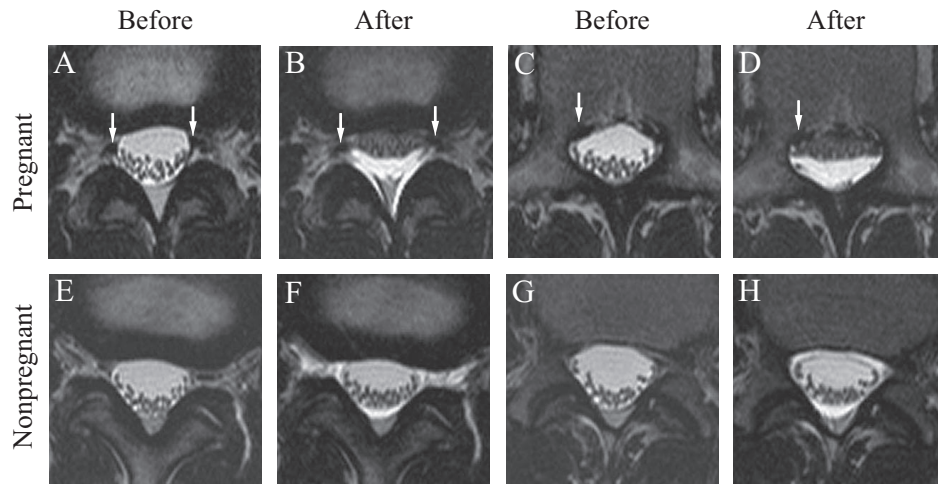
Magnetic resonance (MR) images (A, C, E, G) before and (B, D, F, H) after epidural saline (10 ml) injection in a 27-yr-old pregnant woman at 39 weeks' gestation, whose cerebrospinal fluid volume decreased from 40.5 ml to 30.1 ml (top; A-D), and in a 22-yr-old nonpregnant woman, whose cerebrospinal fluid volume decreased from 35.1 ml to 31.3 ml (bottom; E-H). In these axial images, anterior is at the top of the figure and anatomic right is at the left of the figure. (Top; A-D) The epidural venous plexus was enlarged, which is a common finding among pregnant women (arrows). (A) Axial MR image at the L2–L3 disk level. The dural area at this level was 1.91 cm². (B) Saline accumulated only posterior to the dura and outlined the posterior epidural fat without leaking from the intervertebral foramina. Dural area at this level decreased to 1.03 cm². (C) Axial MR image at the pedicle of L3. The dural area at this level was 2.03 cm². (D) The enlarged epidural venous plexus seemed to block the saline from spreading anteriorly. Dural area at this level decreased to 0.89 cm². (Bottom; E–H) The epidural venous plexus was not enlarged in the nonpregnant women. (E) Axial MR image at the L2–L3 disk level. The dural area at this level was 1.86 cm². (F) Saline spread around the dural sac, except for the anterior portion, and leaked through the intervertebral foramina. Dural area at this level decreased to 1.63 cm². (G) Axial MR image at the pedicle of L3. The dural area at this level was 2.16 cm². (H) After 10 ml saline was injected, the saline encircled the dura. Dural area at this level decreased to 1.91 cm².
